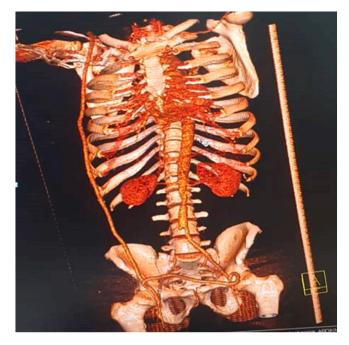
Post op, CT angiography revealed extra-anatomical bypass graft. Axillo-bifemoral graft and right main iliac occlusion.
